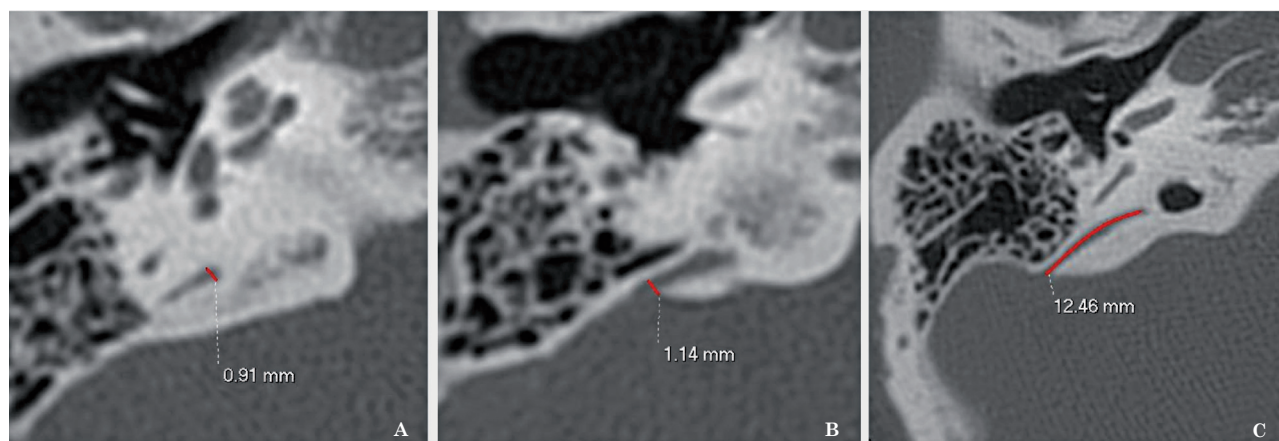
Axial orbitomeatal CT images with measurements of the vestibular aqueduct: A) VA width measured at the midpoint between the external aperture and common crus; B) external aperture width; C) VA length.
